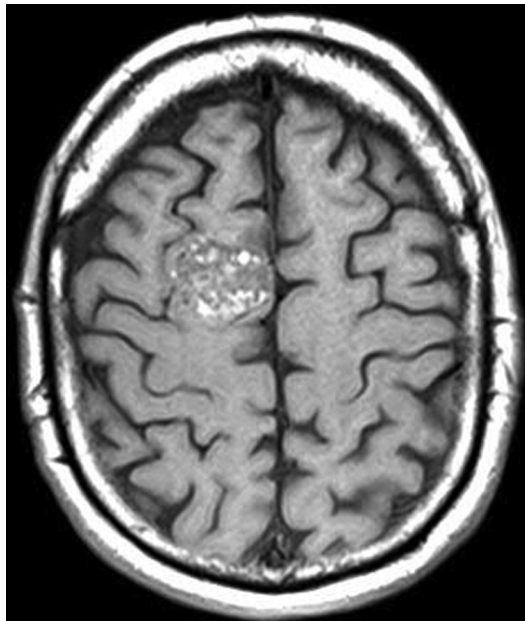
Patient with right supplementary motor area seizures. MRI head T1-weighted image in the axial plane shows a right mesial frontal cavernous malformation. Note the right frontal lobe is on the left side of the figure.
